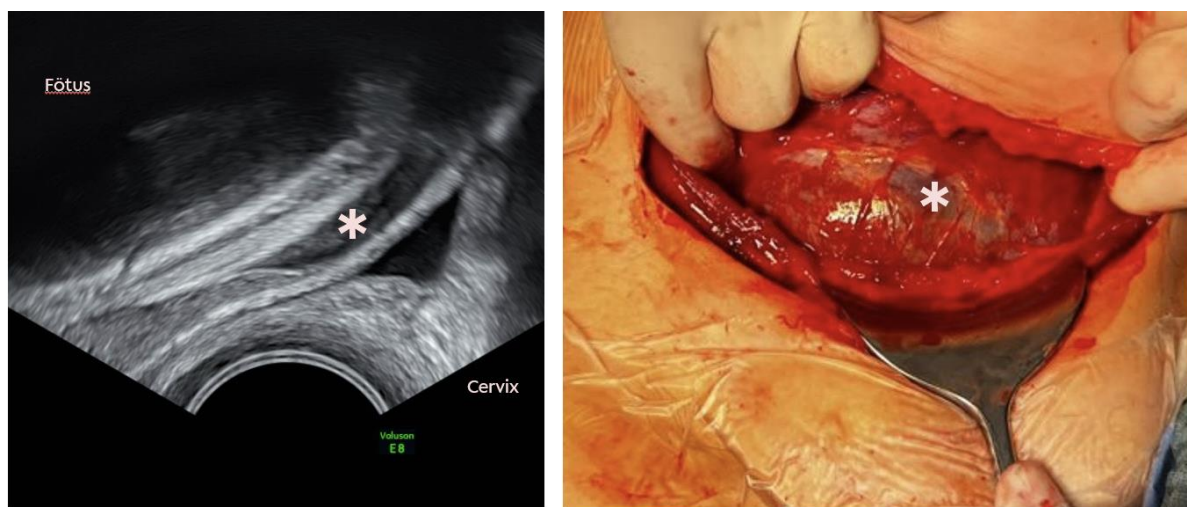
Klinisches Bild einer uterinen Dehiszenz. Links sonographische Darstellung der Unterbrechung des Myometriums im unteren Uterinsegment (*), rechts das klinische Bild der uterinen Dehiszenz (*) im operativen Situs. Das Intervall zwischen den Schwangerschaften lag bei der Patientin bei unter zwölf Monaten. Aufnahmen von der Autorin. Mit freundlicher Genehmigung der Patientin.
